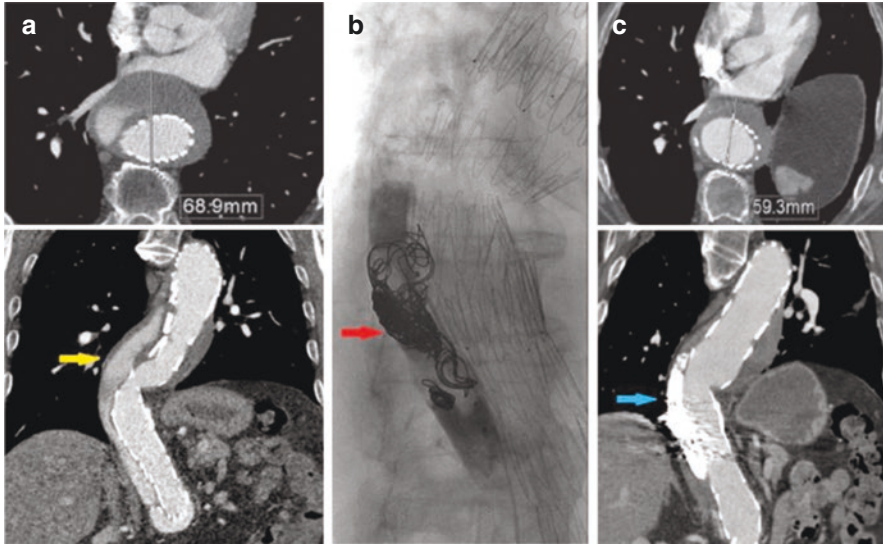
Coil embolization and glue injection of a patent false lumen. Large patent false lumen following TEVAR (a). Deployment of coils and injection of glue in the false lumen (b, red arrow). Postoperative CTA showing thrombosed false lumen and decreased total aortic diameter (c)
